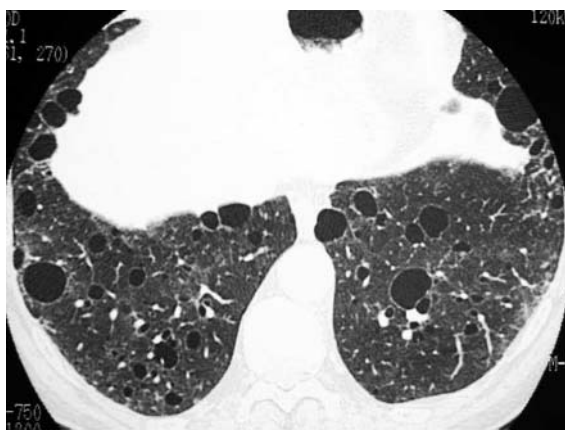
Lymphocytic interstitial pneumonia in a patient with Sjögren's syndrome. HRCT scan demonstrates bilateral thin-walled cystic lesions in the lower lobes in a random distribution.
